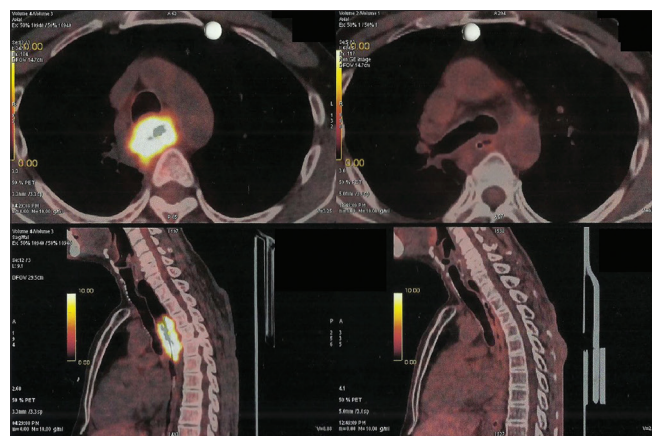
Pre- and postchemoradiotherapy positron-emission tomography-computed tomography scans showing complete metabolic response in a patient of carcinoma of the upper thoracic esophagus
